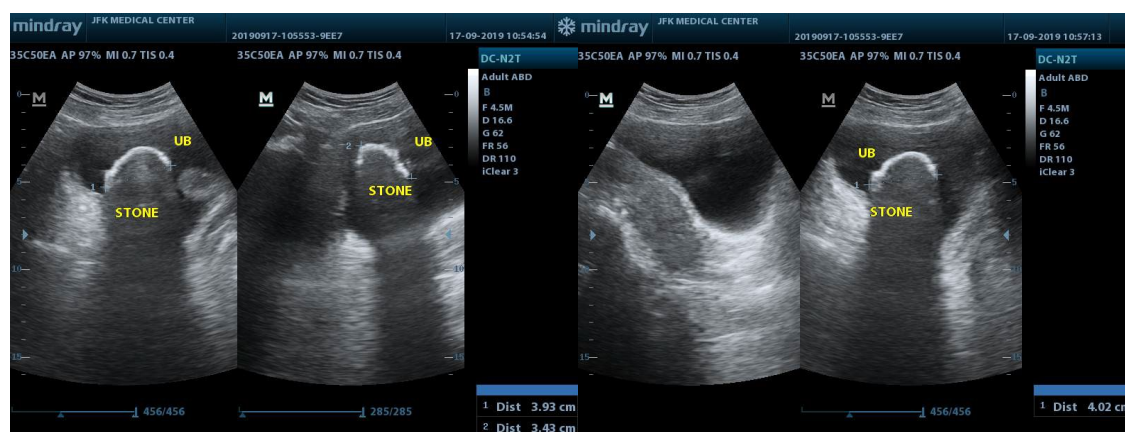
Abdominopelvic ultrasound revealed an echogenic focus casting dense posterior acoustic shadow in the bladder. It measured 7 cm by 5 cm, with irregular surface leading to a diagnosis of bladder stone.
